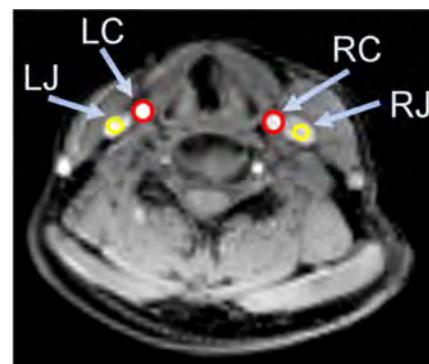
Regions of interest on MR imaging used for PET TBR calculations. LC: Left Carotid; RC: Right carotid; LJ: Left Jugular; RJ: Right Jugular.
